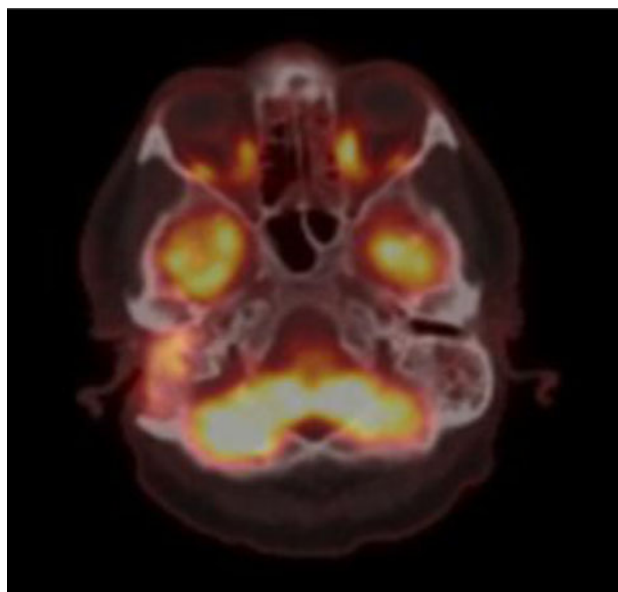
Axial fluorine-18 fluorodeoxyglucose (FDG) positron emission tomography/computed tomography (18F-FDG-PET/CT) scan, revealing increased FDG uptake in the obliterated area of the right middle ear and mastoid, without FDG uptake in the contralateral mastoid.
